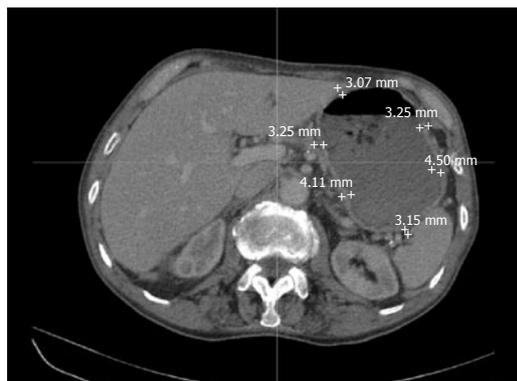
Typical gastric wall thickness measurements on transverse plane CT scan using electronic callipers.
